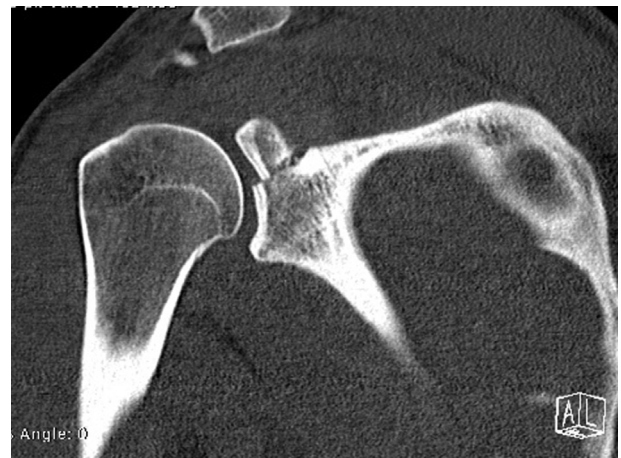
Preoperative computed tomography of the right shoulder (coronal view), showing the glenoid fracture Ideberg type III, characterized by a transverse fracture line through the glenoid cavity.
